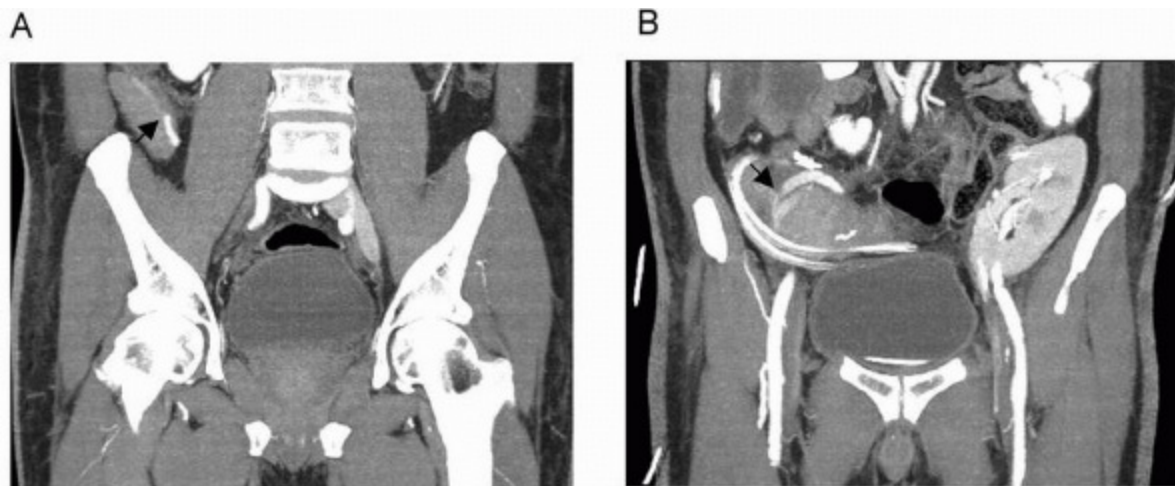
Computed tomographic angiogram of pancreatic allograft. Arrow demonstrates thrombosis of distal splenic artery (A) and distal SMA superior mesenteric artery of the allograft. Note that the gland is well perfused because of collateral blood flow.
